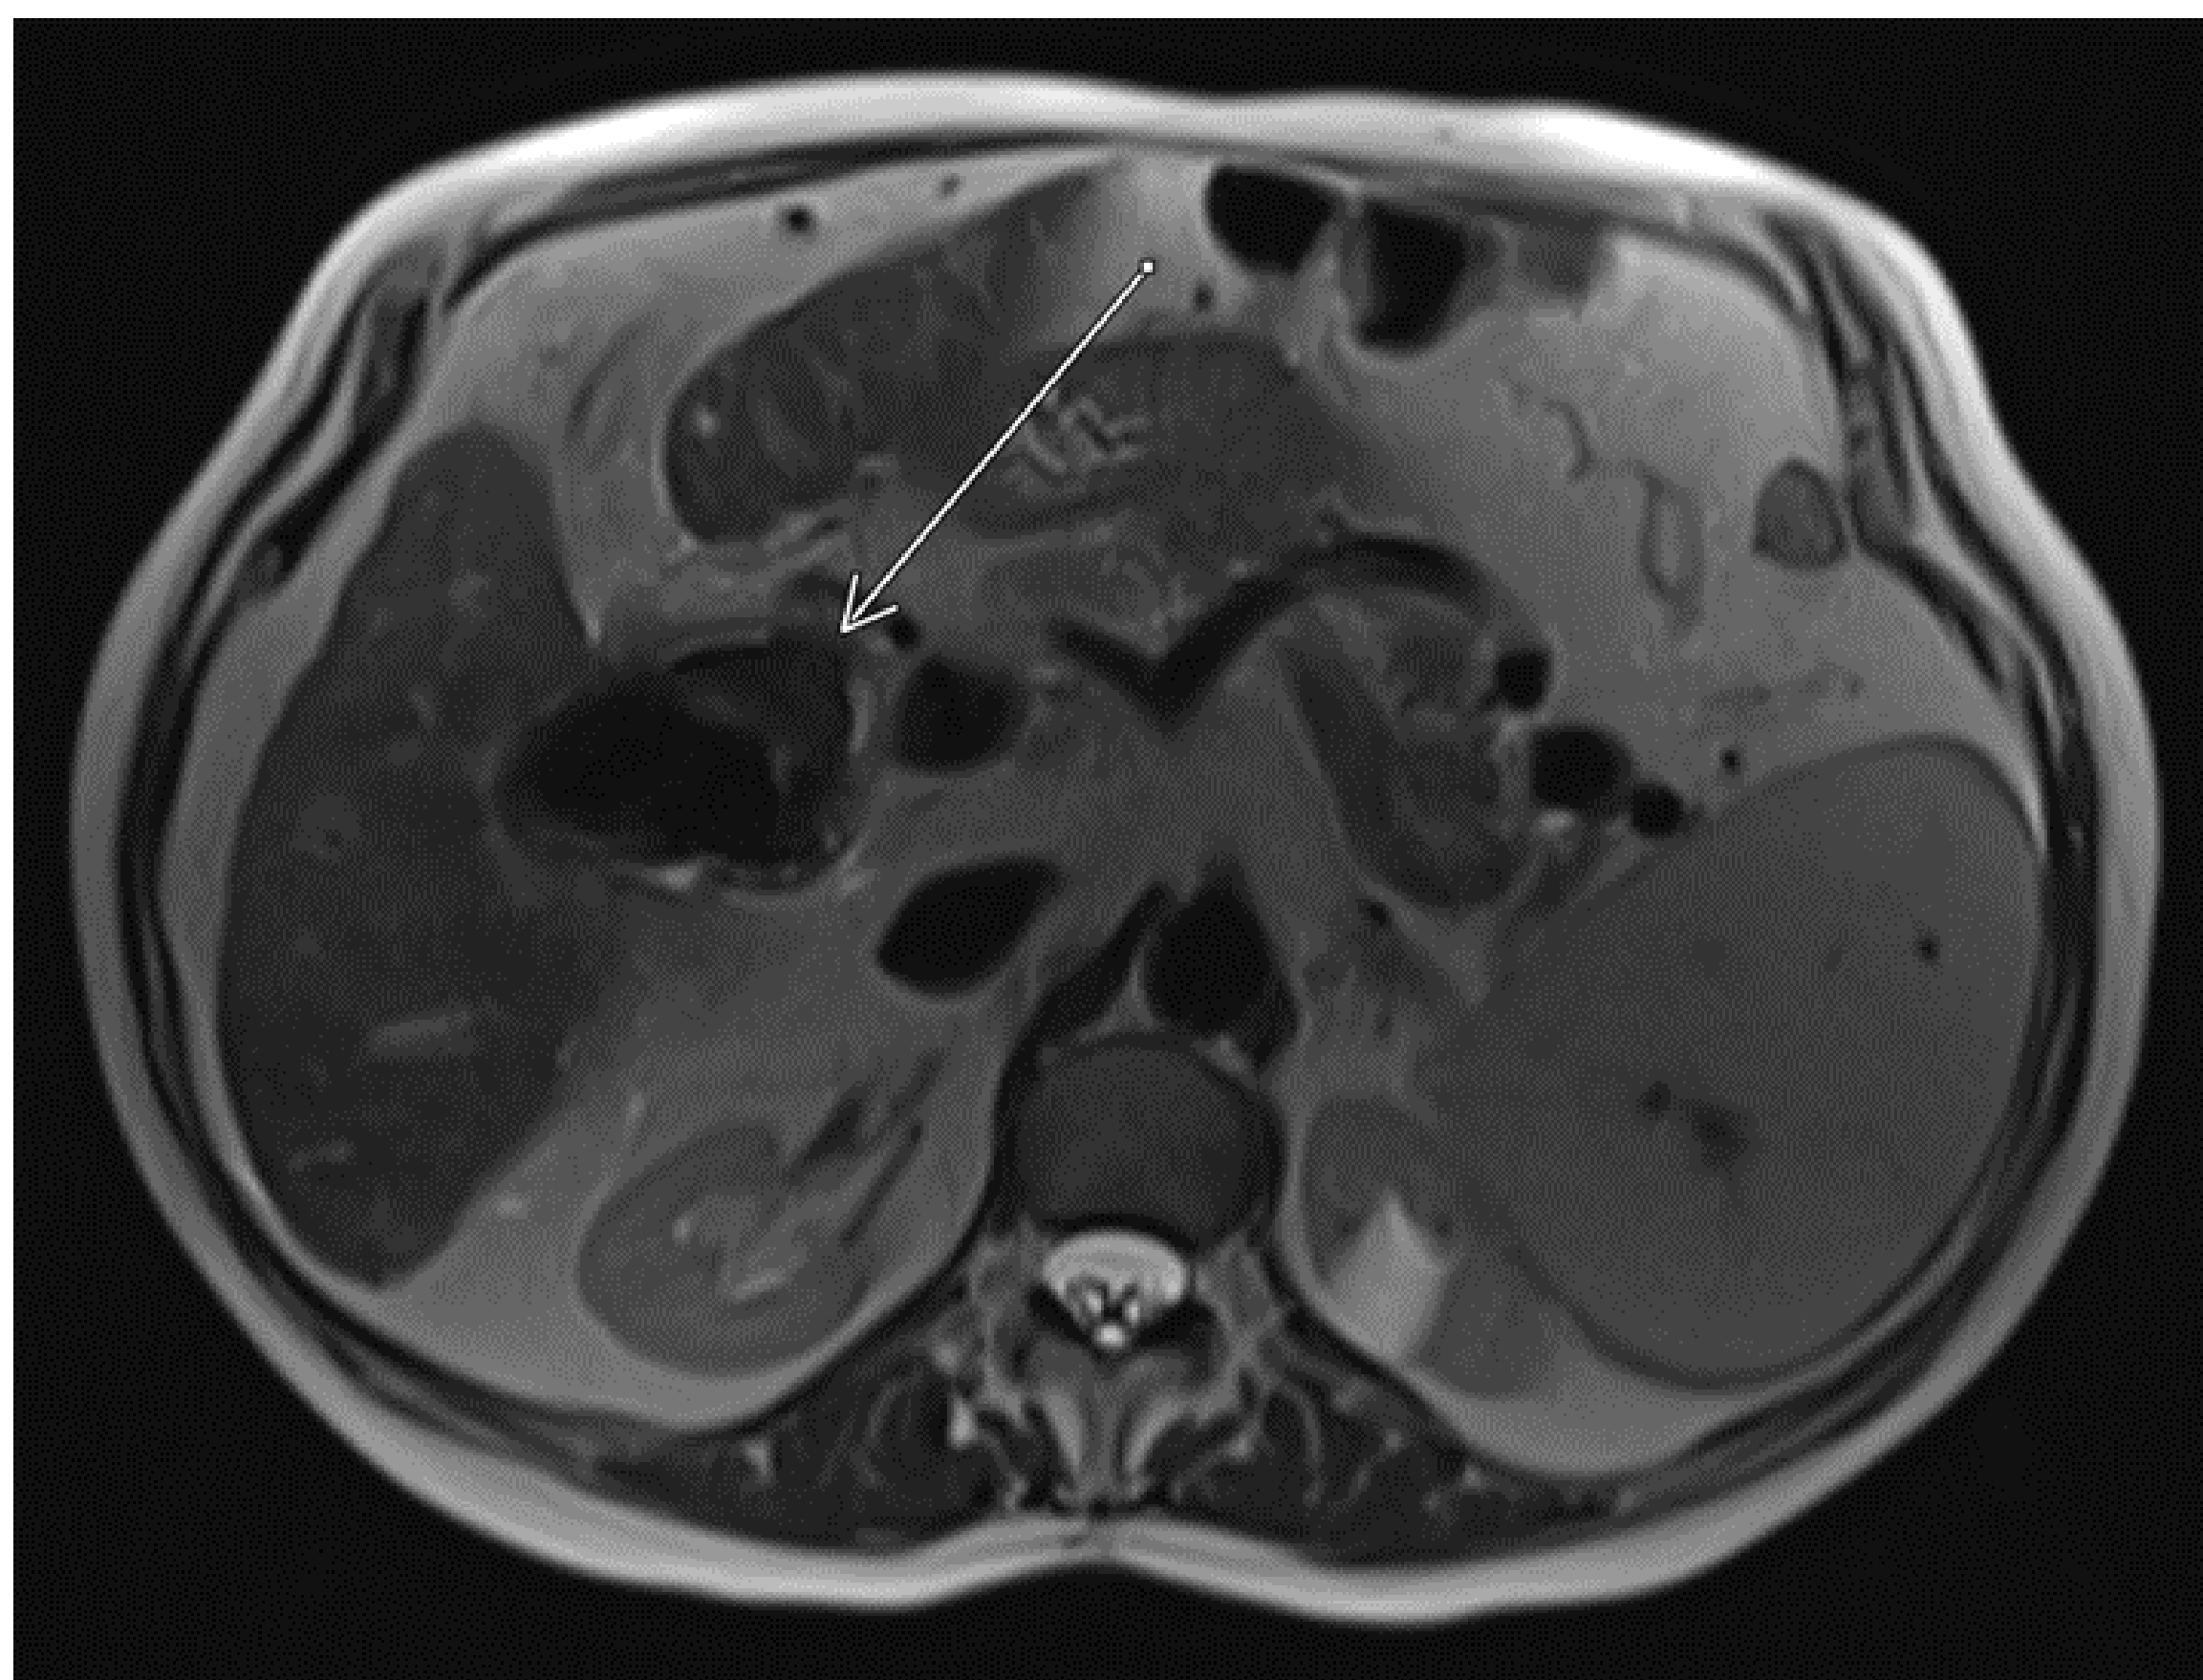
MRI Demonstrating Indistinct Wall Between Gallbladder Neck and Common Bile Duct with Pneumobilia
